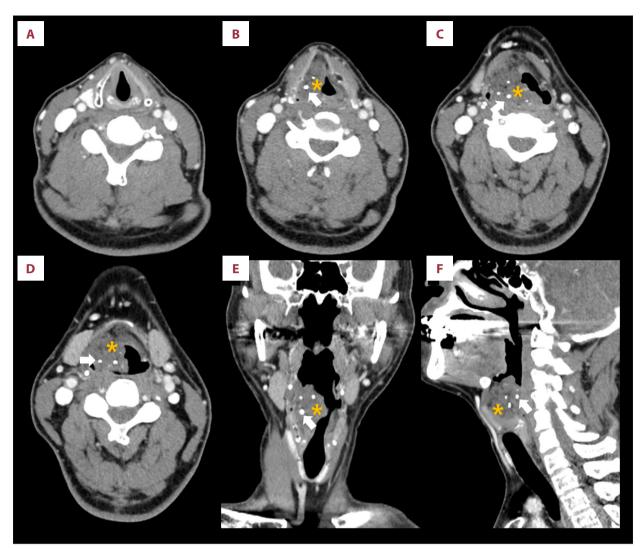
Representative preoperative computed tomography (CT) of the neck with contrast enhancement. (A) The true vocal fold and subglottis were not involved by the tumor (axial image). A 38×22×32-mm irregular lobulated soft tissue density mass (asterisk) with multiple calcifications (white arrow, phleboliths) was detected on an axial image (B-D), coronal image (E), and sagittal image (F).
